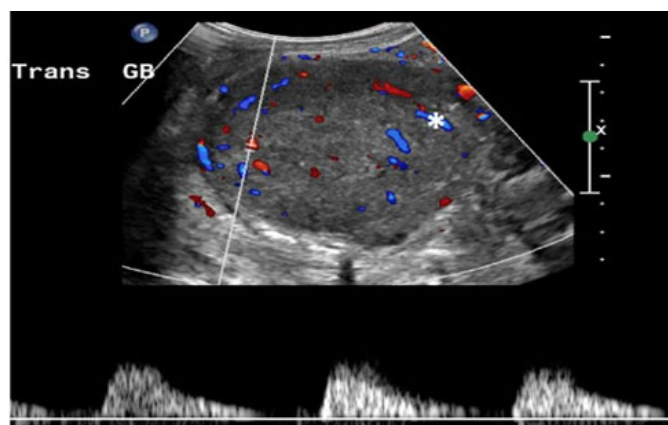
Right upper quadrant (RUQ) ultrasound showing gallbladder mass with internal blood flow (asterisk).
